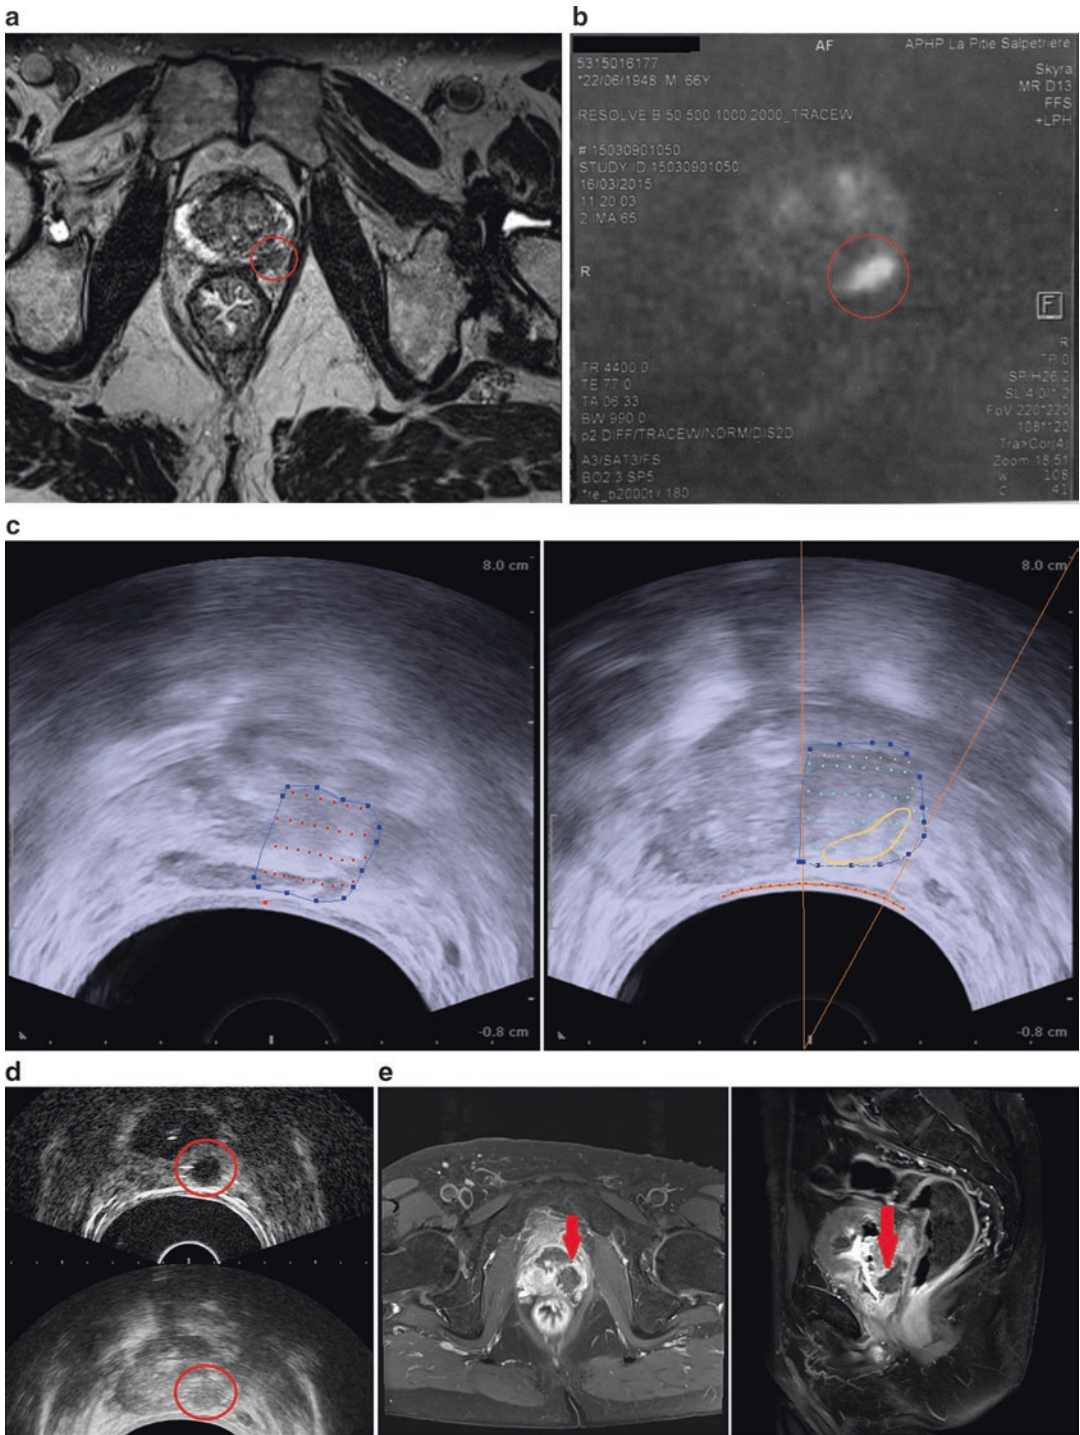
The three pillars of focal therapy: planning, treatment, and control. (a) Coronal view: T2-weighted magnetic resonance images (MRI). *Red circle* indicates tumor outlines. (b) Coronal view: diffusion-weighted MRI. *Red circle* indicates region of interest (ROI) for ablation. (c) Coronal view (*left panel*): ultrasound images during ablation treatment. High-intensity focused ultrasound. Coronal view (*right panel*): ultrasound images during ablation
